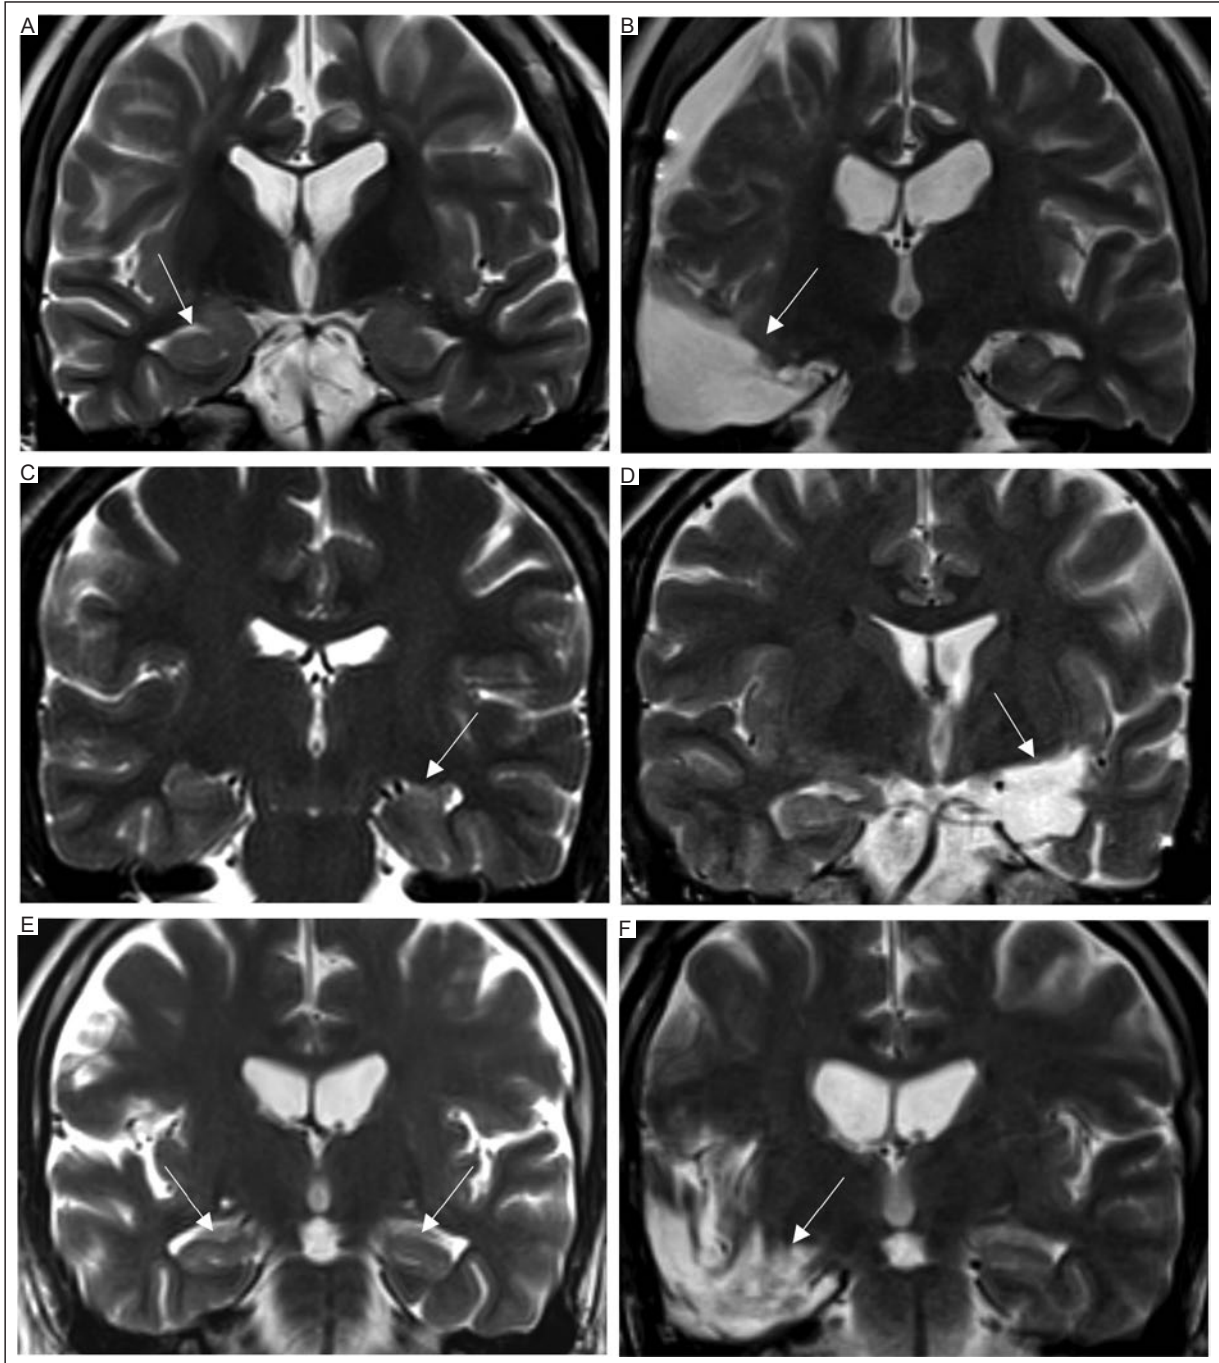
Preoperative and postoperative MRI findings of the patients with refractory TLE who underwent epilepsy surgery. A: abnormal preoperative coronal T2-weighted view of a 21-year-old man with atrophy and increased signal intensity in the right hippocampus (arrow). B: postoperative coronal T2-weighted view with changes secondary to right temporal lobectomy with right amygdalohippocampectomy. A residual hygroma is seen in the subarachnoid space of the frontal and temporal convexity (arrow). C: abnormal preoperative coronal T2-weighted view of a 32-year-old woman with atrophy and increased signal intensity of the left hippocampus (arrow). D: postoperative coronal T2-weighted view with changes secondary to amygdalohippocampectomy with an area of encephalomalacia and areas of gliosis at the left temporal level (arrow). E: normal preoperative coronal T2-weighted view of a 58-year-old man with normal volume and signal intensity in the bilateral hippocampus (arrow). F: postoperative coronal T2-weighted view with an area of encephalomalacia and gliosis in the right temporal level (arrow).
